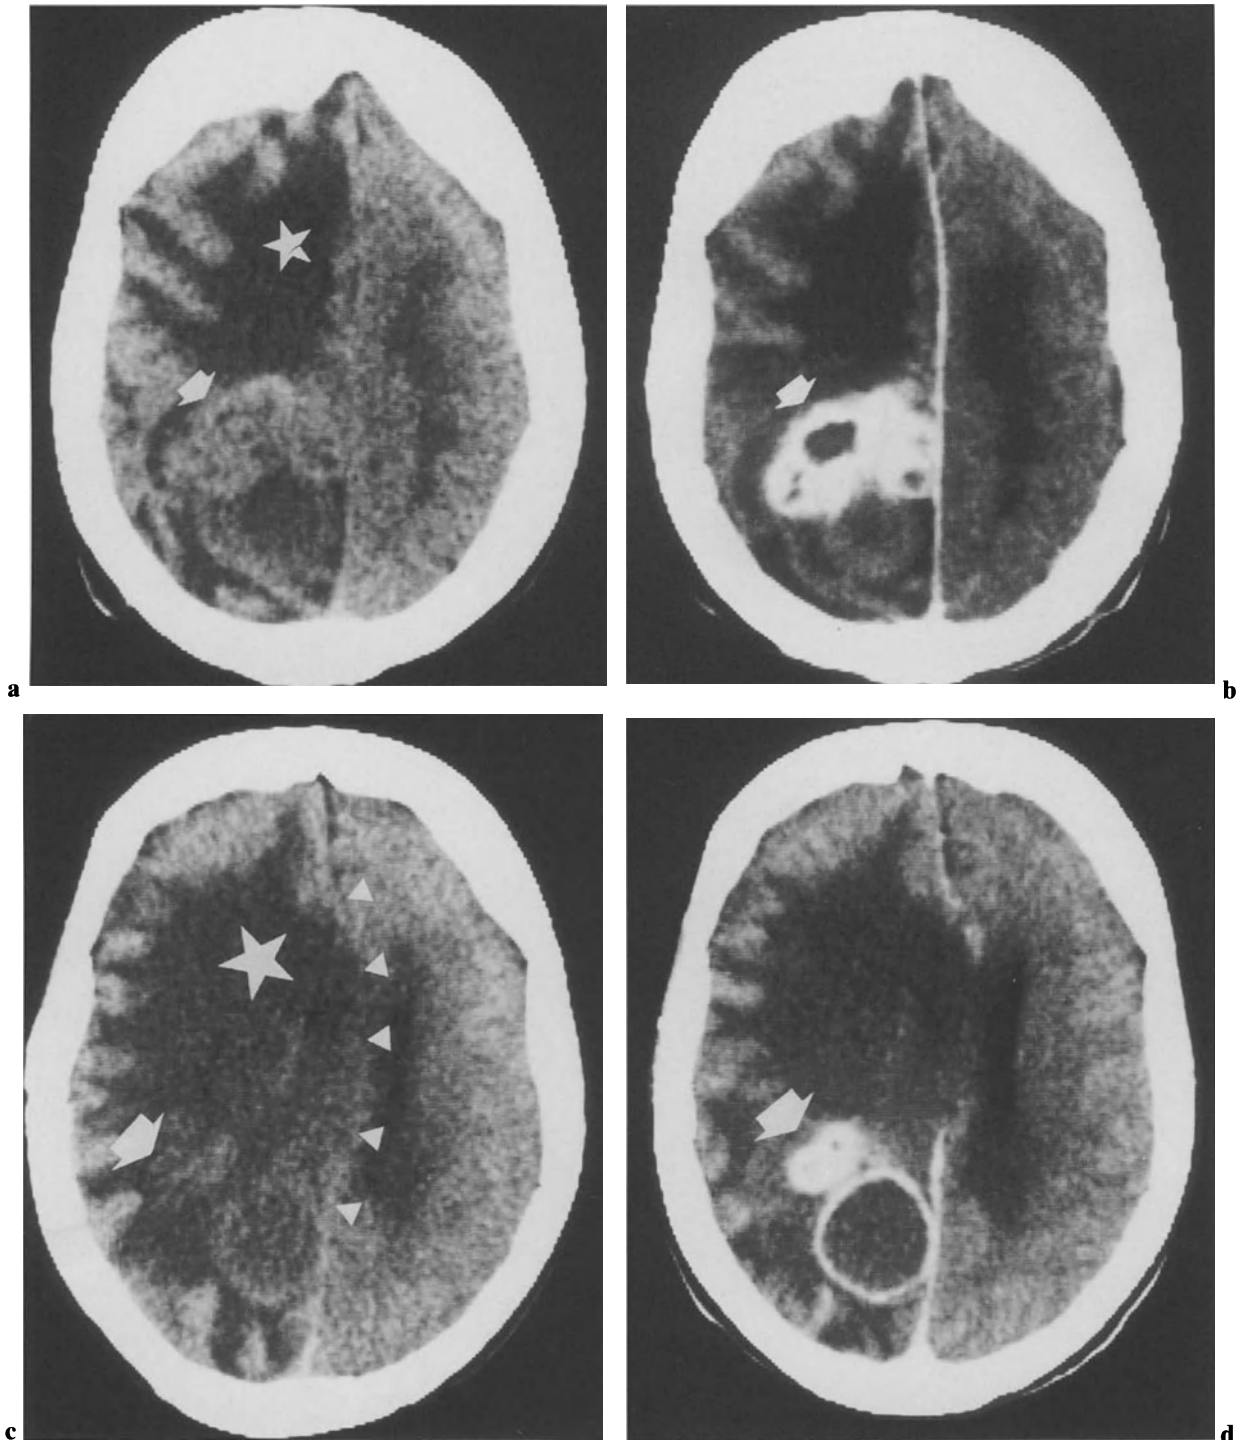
a–d. CT appearance of a giant tuberculoma, observed in a mentally ill, not HIV-infected patient. Unenhanced CT (a, c) shows considerable midline shift (*white triangles*), extensive perifocal edema (*white asterisk*), and the tuberculoma as a mass
